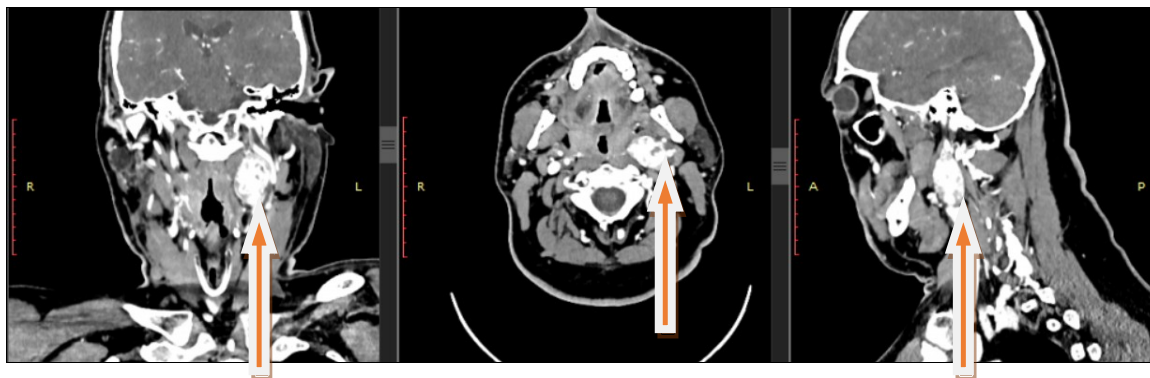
Coronal, axial, sagittal section on postcontrast CT examination
